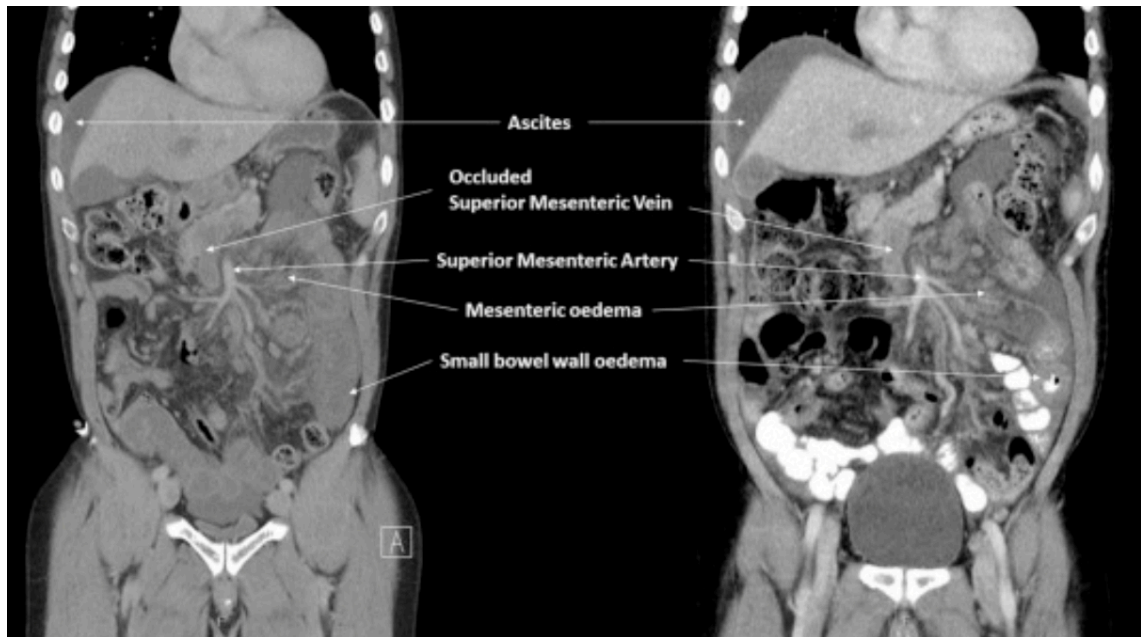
MVT and other common intestinal findings in abdomen CTA
